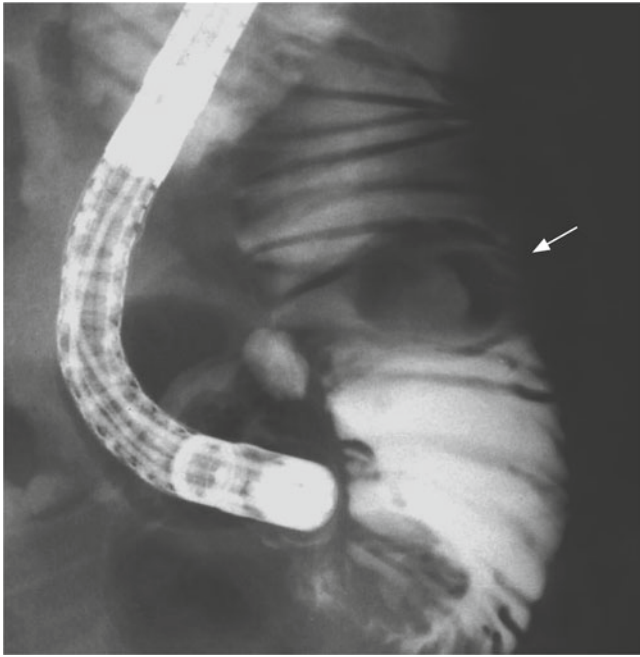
Jejunal radiography revealed a filling defect with clear margins and a barium fleck in the center
